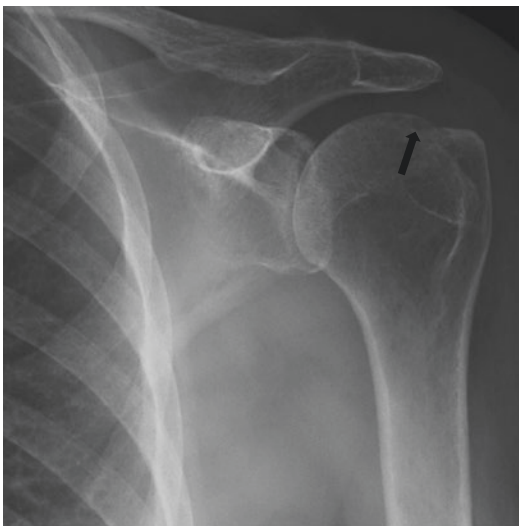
47-Year-old patient with RA. Frontal radiograph demonstrates the erosion at the humeral head at the typical location of bare area (black arrow)
